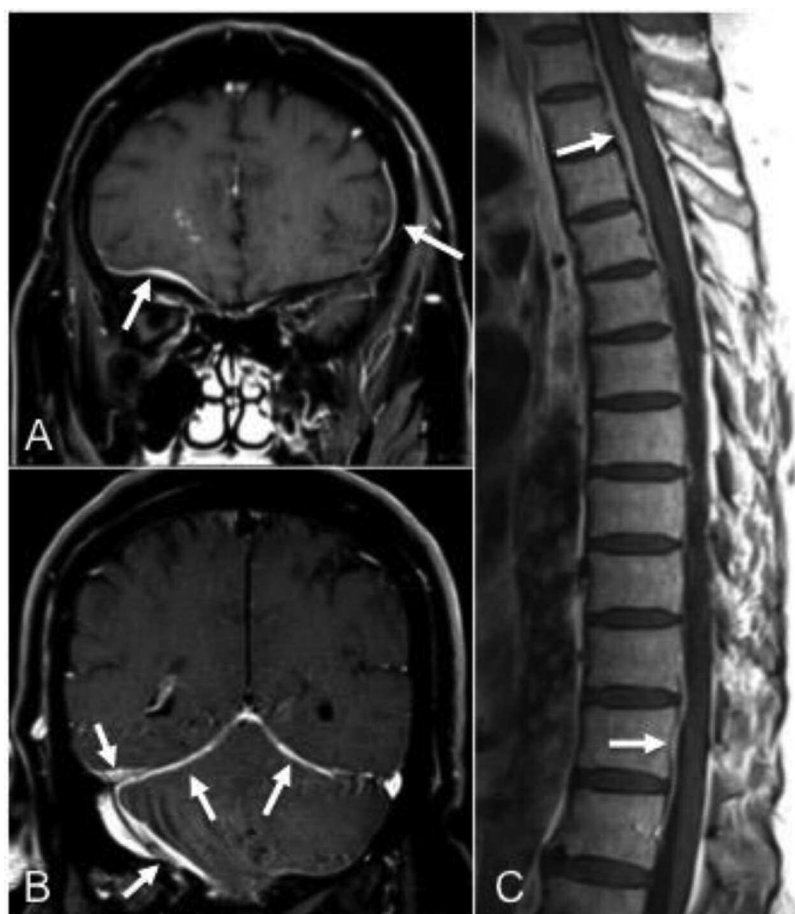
Coronal fat-suppressed postcontrast T1-weighted images (A, B) through the brain demonstrate abnormal pachymeningeal enhancement involving the floor of the right anterior cranial fossa and the left frontal convexity (arrows in A), and along the bilateral tentorial leaflets and the right lateral aspect of the posterior fossa (arrows in B). The punctate foci of enhancement in the frontal lobe are because of an incidental developmental venous anomaly (A). Sagittal postcontrast T1-weighted image of the thoracic spine (C) shows pachymeningeal enhancement along the anterior aspect of the thecal sac (arrows in C).
